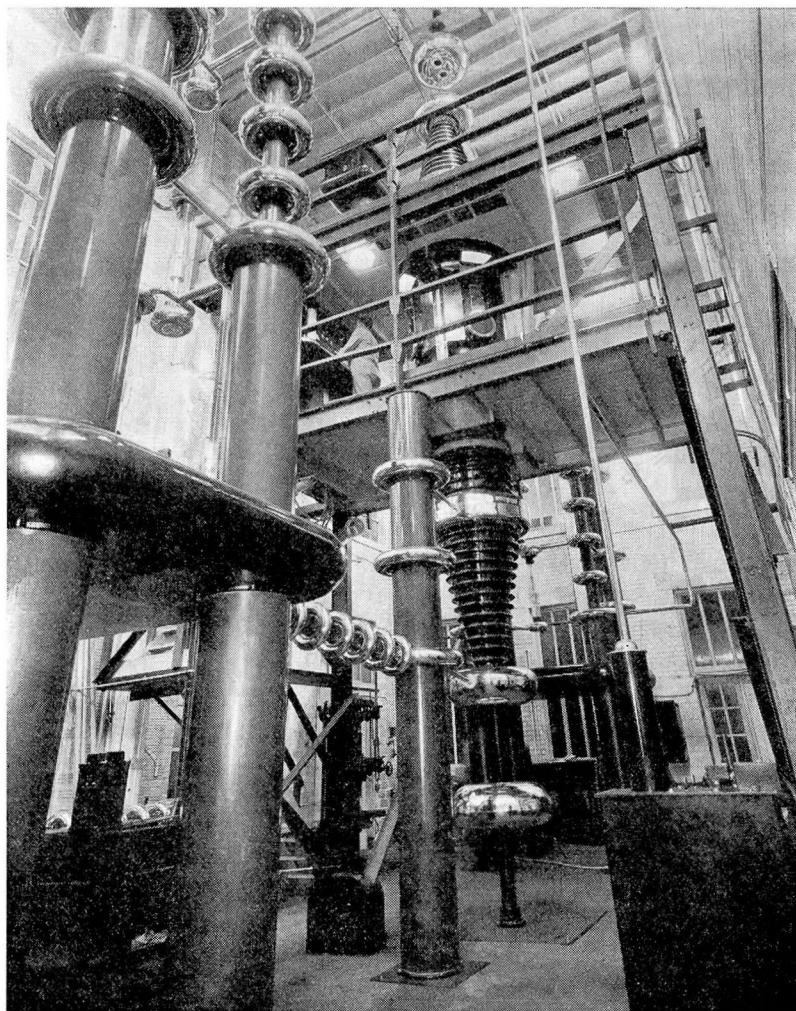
Kelley Koett 1200 KV roentgen ray constant potential transformer generator with double Crane-Lauritsen porcelain tube. For comparative size, note operator at switch-board on platform.
